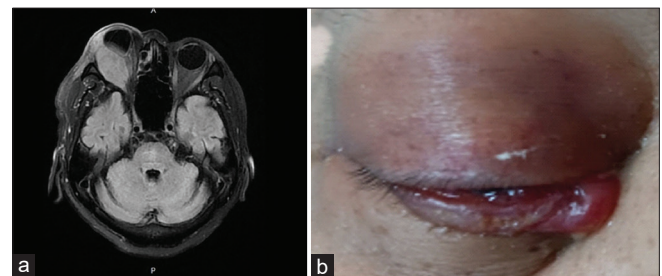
Brain magnetic resonance imaging (a: T2 FLAIR) and photo of the right eye (b) showing orbital metastases before enfortumab vedotin treatment
